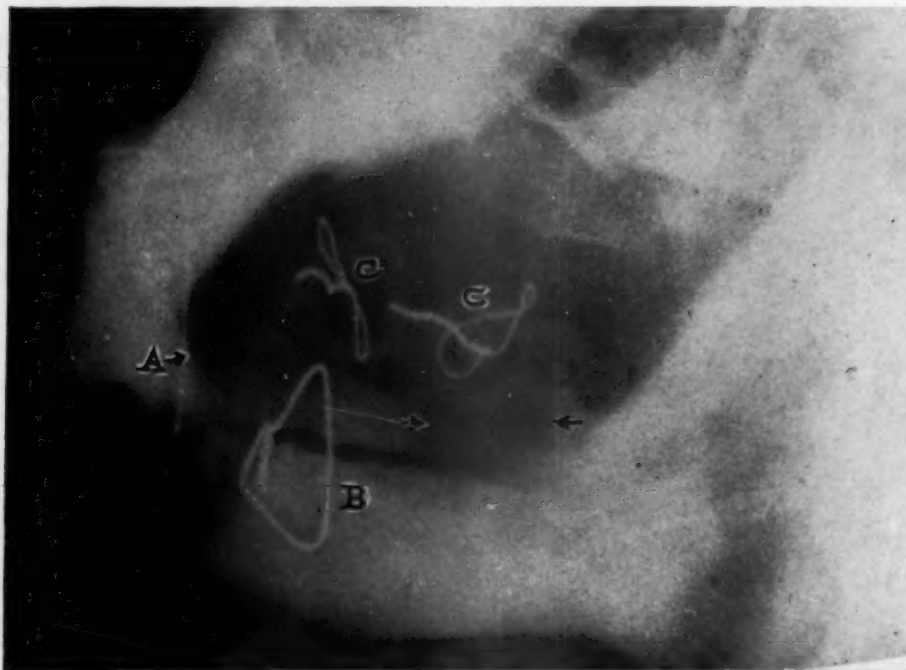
Postoperative x-ray showing result of sliding osteotomy. Space gained between arrows measured 1 inch. A, Circumferential wire at symphysis; B, tantalum wire to hold the two fragments; C-C, wires to fasten the two splints together.
